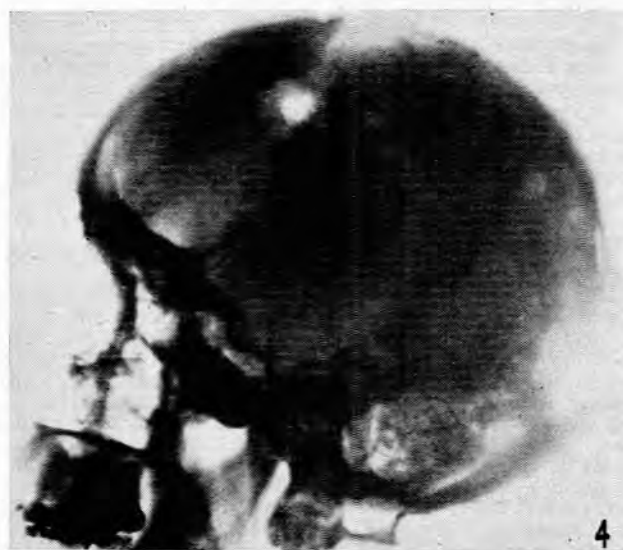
X-ray of skull on 16 November 1954.
